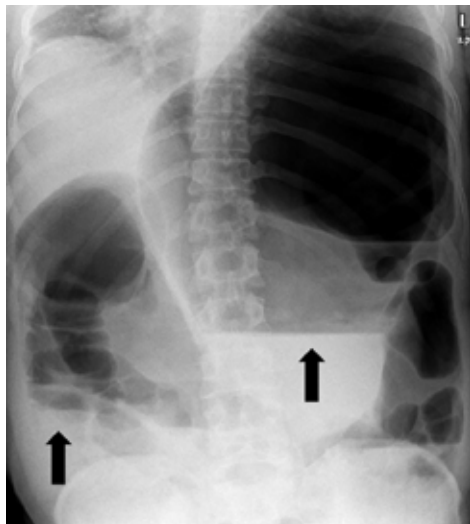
Plain x-ray of abdomen showing 2 widely separated air fluid level in the cecum and distended splenic flexure (arrows).
